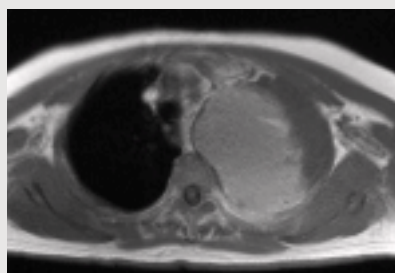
T1-weighted image
